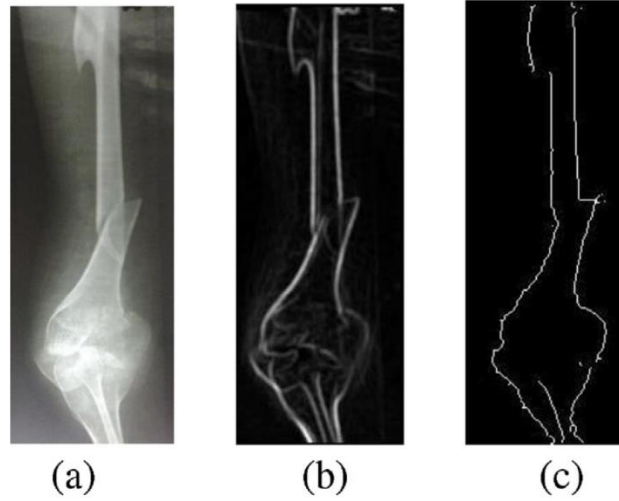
[41] - (a) Original digital x-ray of broken femur, (b) pre-processing using local entropy computation and (c) contour generation based on the image obtained in (b)
